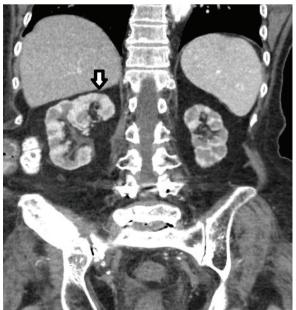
Coronal plane computed tomography shows supernumerary kidney just above the right kidney and fused with upper pole (arrow)
